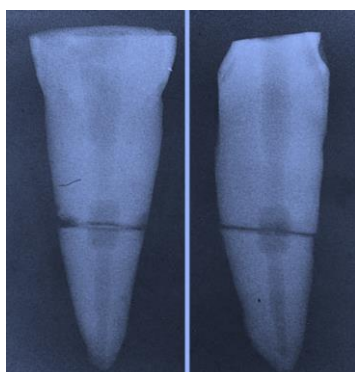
Radiograph showing
